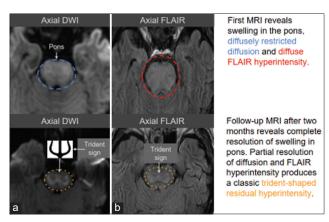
Magnetic resonance imaging reveals swelling in the pons, (a) diffusely restricted diffusion, and (b) diffuse fluid-attenuated inversion recovery hyperintensity
